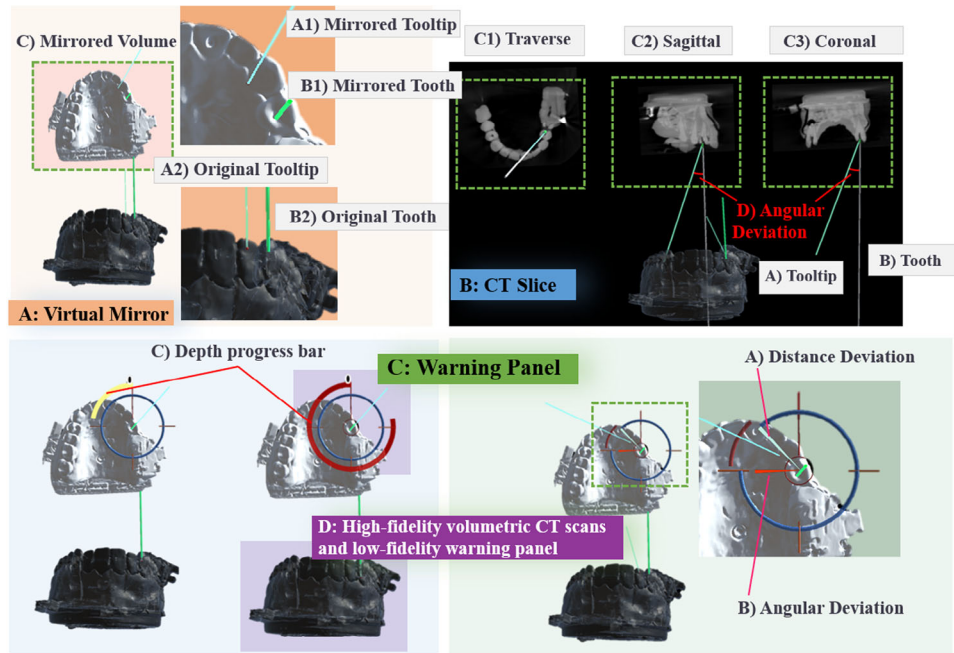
(a) Virtual mirror: a virtual mirror mirrors the real-size tooth and tooltip to face the clinicians. (b) CT slices: the CT slices contain visual indicators of angular deviation and relative location of the tool. (c) Warning panel: a scalable and movable ring-shaped warning panel displays the following information: (a) Relative distance is shown with a green pointing line. (b) Angular deviation is shown with an arc of the ring and a red pointer, and (c) Depth is shown with a colour-coded progress bar. (d) Fidelity: high-fidelity objects have more perceptual differences than low-fidelity objects.
